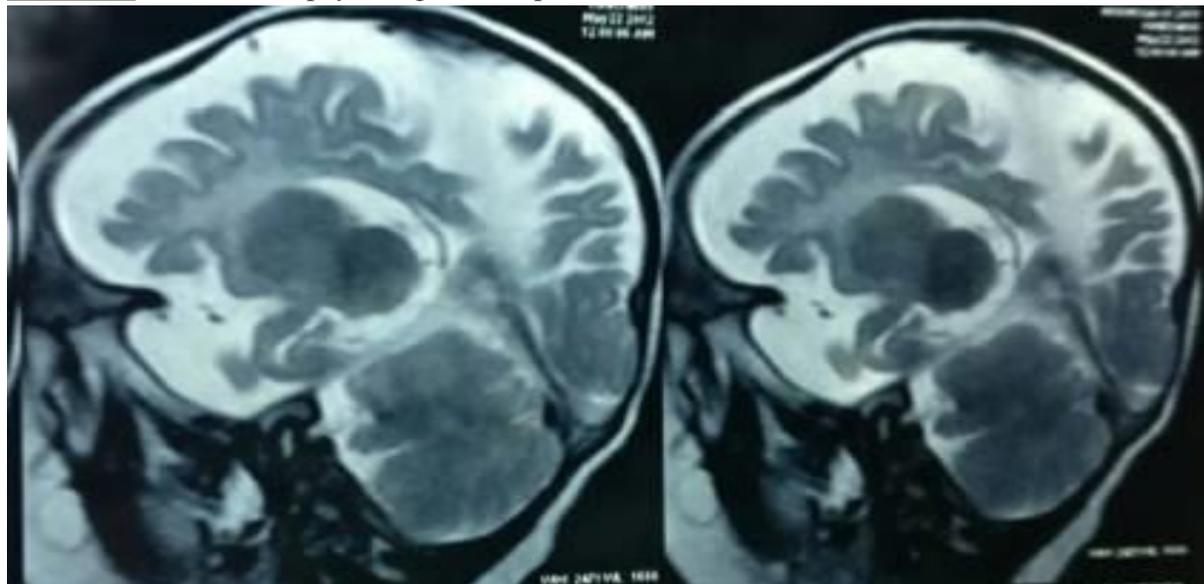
Diffuse bilateral white matter changes seen in MRI of the patient.
